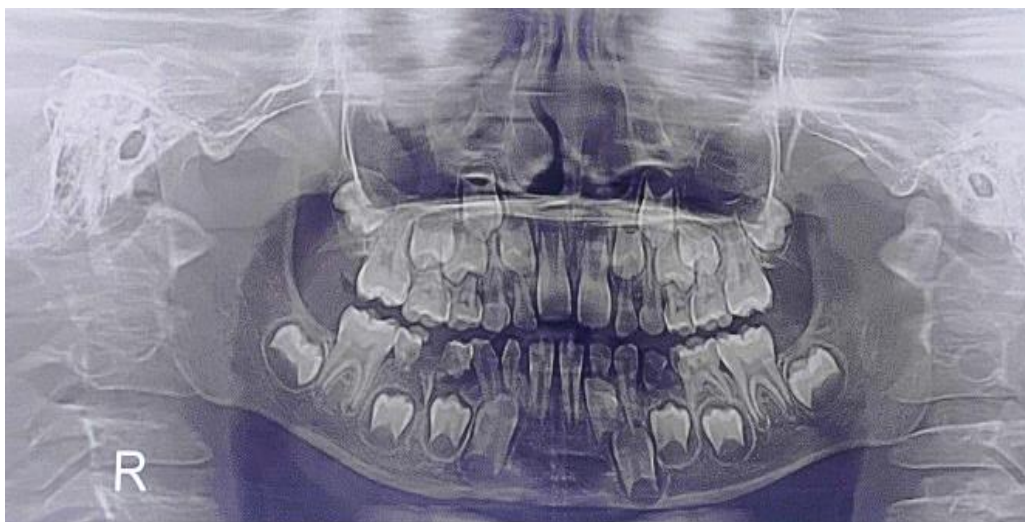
Panoramic radiographic image of the patient
